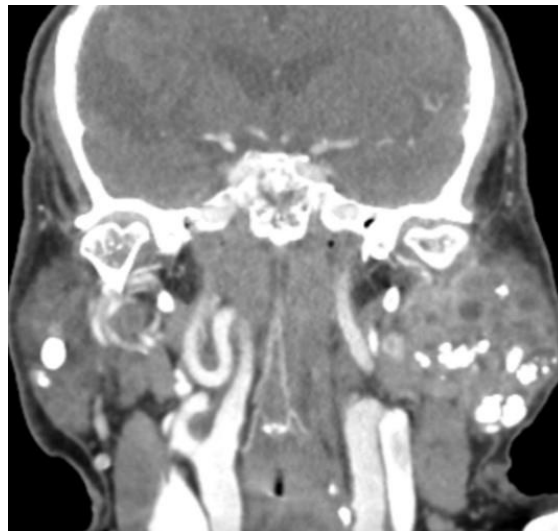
Coronal section of contrast-enhanced neck computed tomography obtained in 2025. More than 20 calculi are observed in both parotid glands, with the largest stone measuring approximately 17 mm. Cystic dilatations consistent with sialectasia are present within the parenchyma.
